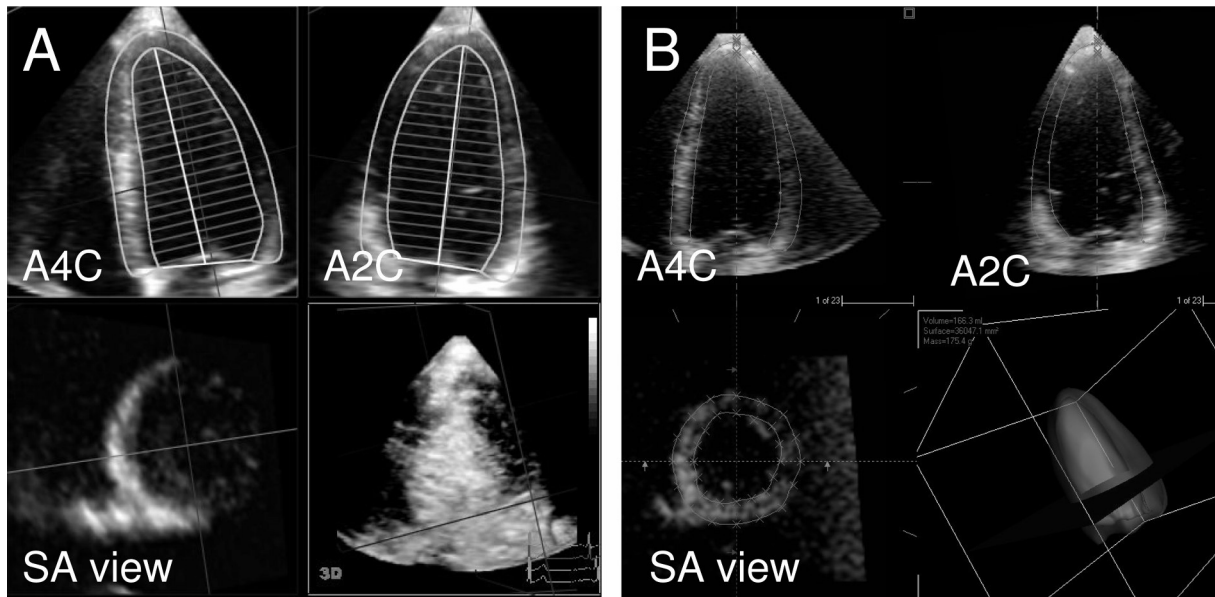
(A) Biplane analysis: an example of anatomically correct LV apical views from the RT3DE data set by 3DQ-Qlab. The red line in the short-axis view corresponds to the apical 2-chamber view and the green line in the short-axis view corresponds to the apical 4-chamber view. (B) Multiplane analysis: an example of endocardial and epicardial tracings in LV apical views by 4D Echo-View. Note the short-axis view (bottom left) showing the tracings corresponding to the long-axis views. A2C = apical 2-chamber; A4C = apical 4-chamber; SA = short-axis.
